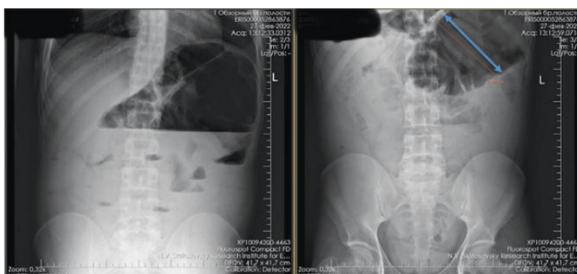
Plain radiography of the abdominal organs on the 6th day of hospitalization
